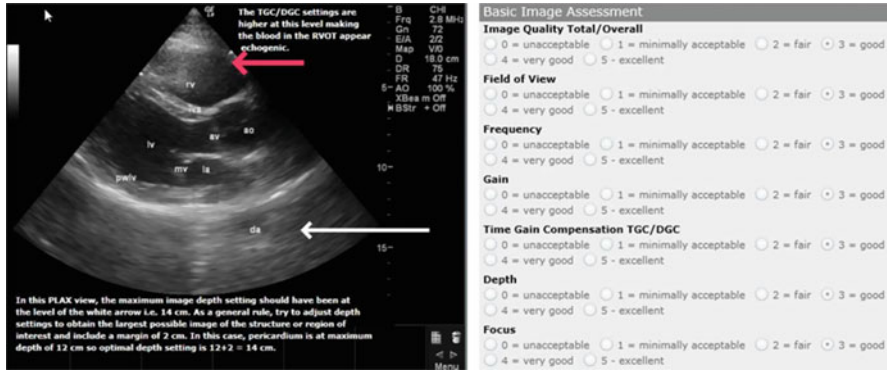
Image assessment. Left panel: a student ultrasound image from a laboratory session in which the student was required to acquire an image of the heart. The reviewer has provided feedback directly on the image. Right panel: a completed standardized image scoring sheet
